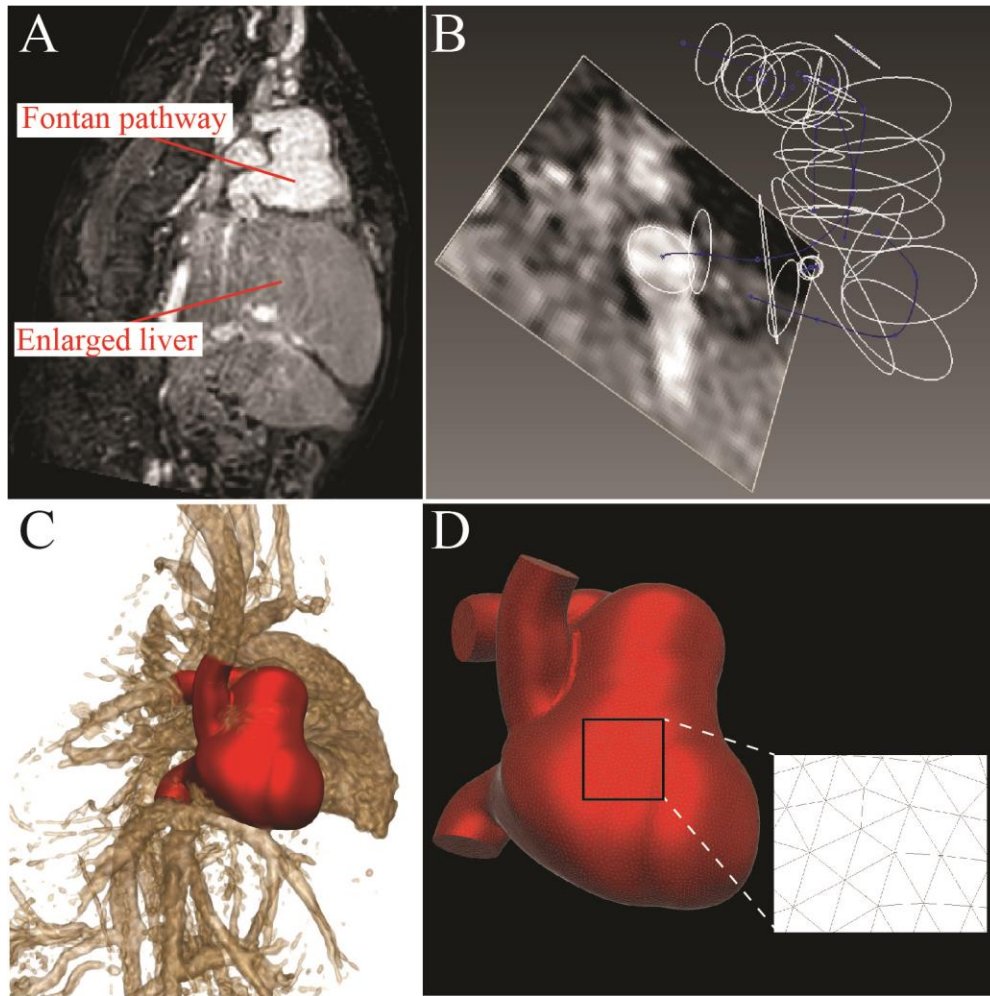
A model of the Fontan pathway was constructed from MRI data (A). Path lines and vessel contours were used to delineate and loft the vessels (B), which were blended to create an anatomical model (C), and subsequently discretized to create a FE mesh.
